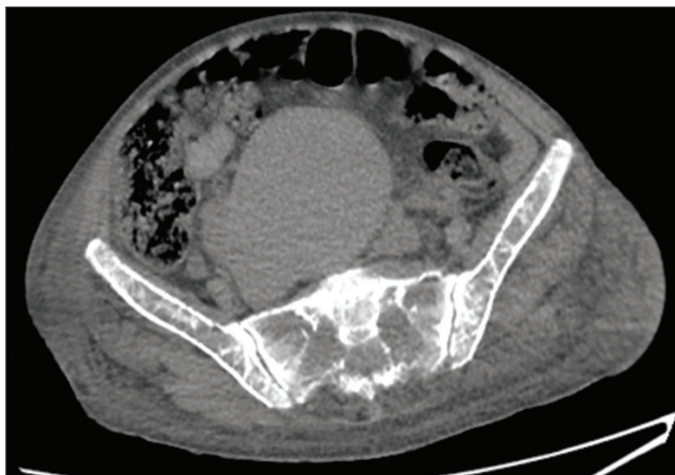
Abdominal computed tomography shows a mass of 155 x 85 mm in the abdomen.
